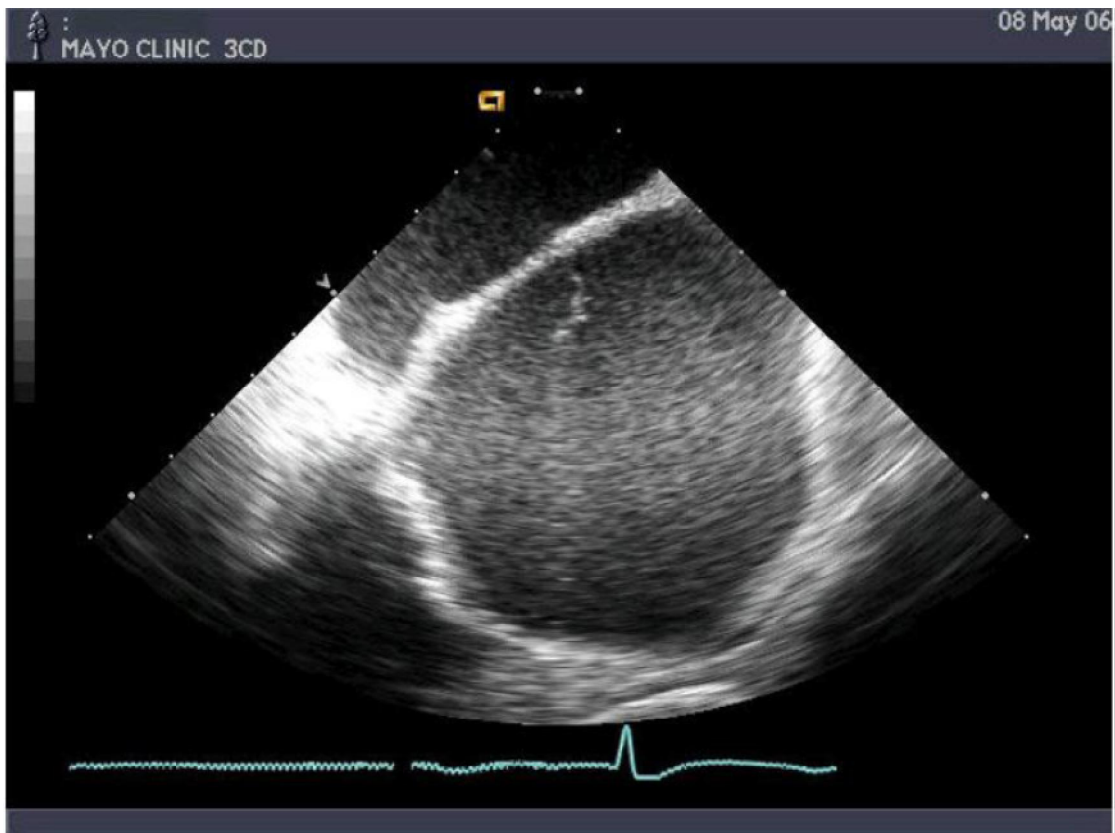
Intracardiac ultrasound using a linear phased-array probe placed in the right atrium visualizing the intraatrial septum and the left atrium. Note a strand-like structure consistent with thrombus noted in the left atrium despite adequate heparinization
